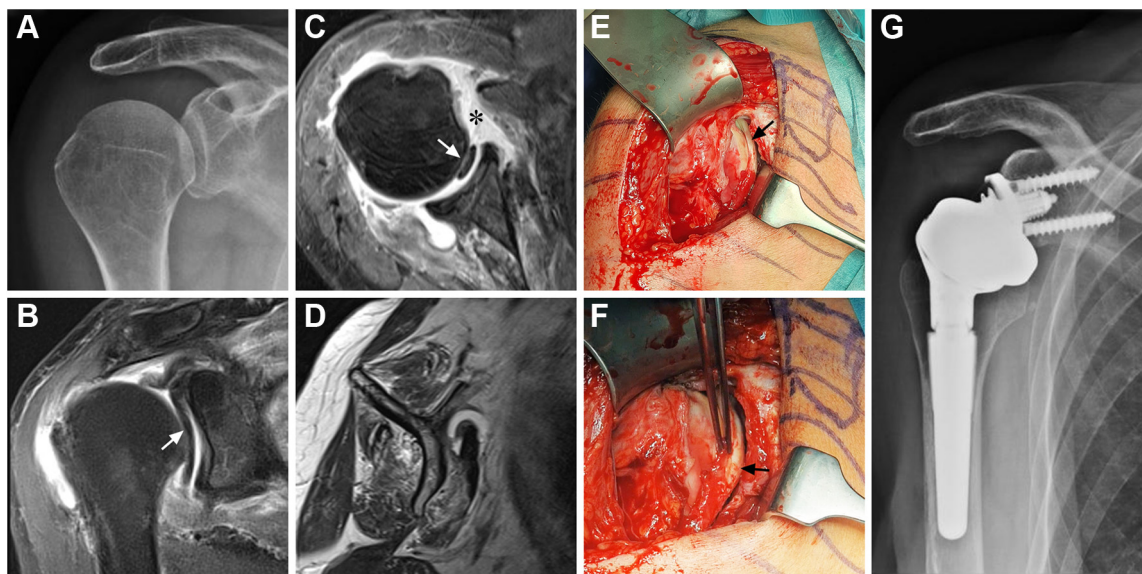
Right shoulder: anteroposterior radiograph (A); MRI T2 weighted oblique-coronal and axial views, showing the entrapped intra-articular biceps tendon (white arrow) and associated massive full-thickness cuff tear, including a retracted subscapularis tear and complete capsular avulsion (*) (B and C); MRI T1 weighted oblique-sagittal view, showing moderate fatty infiltration of the rotator cuff muscles (D); and intraoperative depiction of the dislocated and entrapped biceps tendon (black arrow), after opening of the remaining anterior fascial layer through a deltopectoral approach (E and F).
